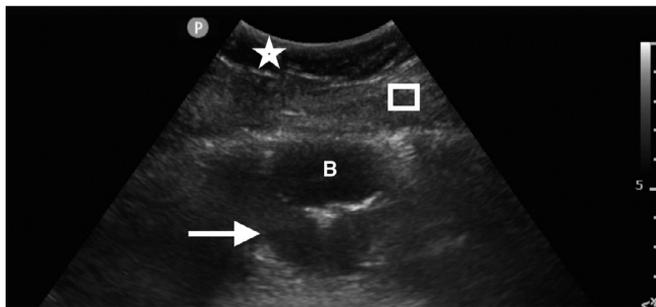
Sonogram shows the gastric tube balloon (B) in place in the stomach at a depth of 3-cm from the skin. Star, subcutaneous tissues; square, rectus abdominis muscle; arrow, balloon mirror artifact
